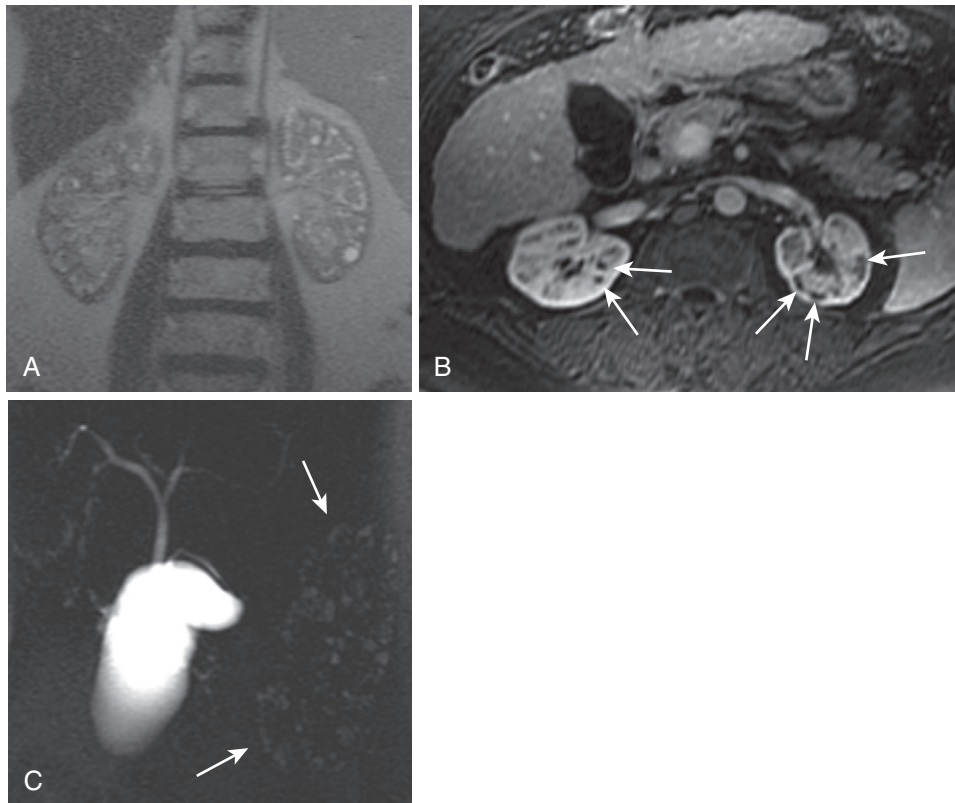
Lithium cystic nephropathy. A, The coronal heavily T2-weighted image shows innumerable punctate simple cysts in the cortex and medulla, most of which measure no more than a few millimeters. B, The postcontrast image confirms cystic etiology through absent enhancement (*arrows*). C, The MRCP image portrays the multiplicity of punctate simple cysts in the left kidney (*arrows*) to better advantage.
